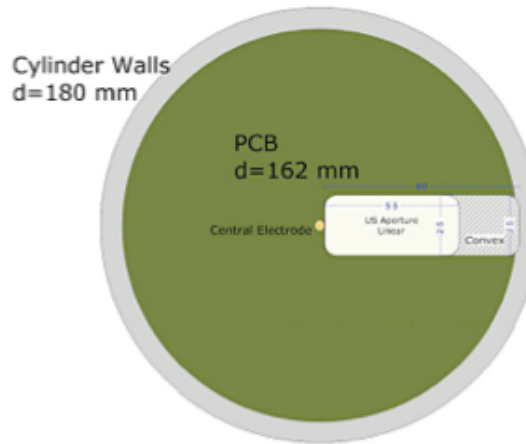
Depiction of the comparison of EIM PCB electrode plate $d=162\text{mm}$; electrode breast plate reaching the scanner inner walls $=180\text{mm}$; a linear (high frequency) ultrasound transducer $55\text{mm} \times 25\text{mm}$; a curvilinear/convex (low frequency) ultrasound transducer $80\text{mm} \times 25\text{mm}$.
